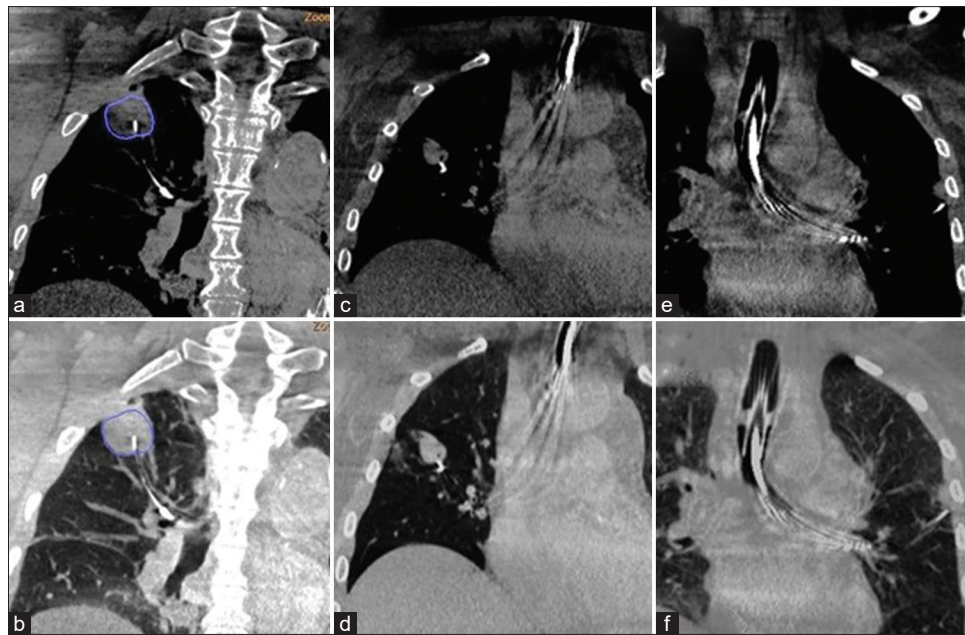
CBCT images showing the different types of tool-in-lesion (TIL) relationships in corresponding mediastinal and lung windows. (a and b) Type 1 (tool within the lesion), (c and d) Type 2 (tool at the lesion's edge or tool touch lesion) (e and f) Type 3 (tool away from the lesion)
